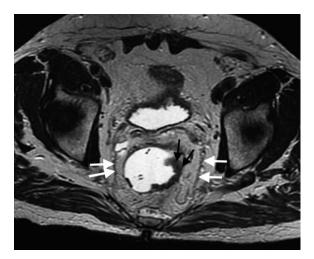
Axial MRI sequence with T2 information. The normal arrangement of the mesorectal fascia is seen on both sides of the pelvis (white arrows) in a patient with a thickening and irregularity of the left lateral wall of the rectum due to a T2 stage colorectal cancer (black arrows).
